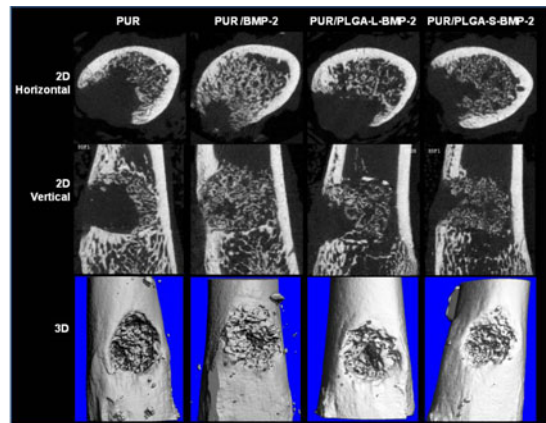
Micro CT images of PUR implants at week 4.
